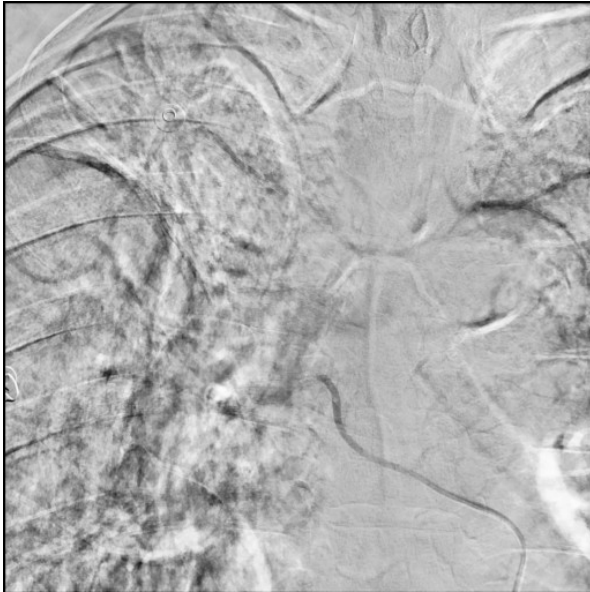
Bronchial angiography detected bronchial artery hypervascularity in the right upper lobe, corresponding to the bronchiectasis noted on chest computed tomography.
